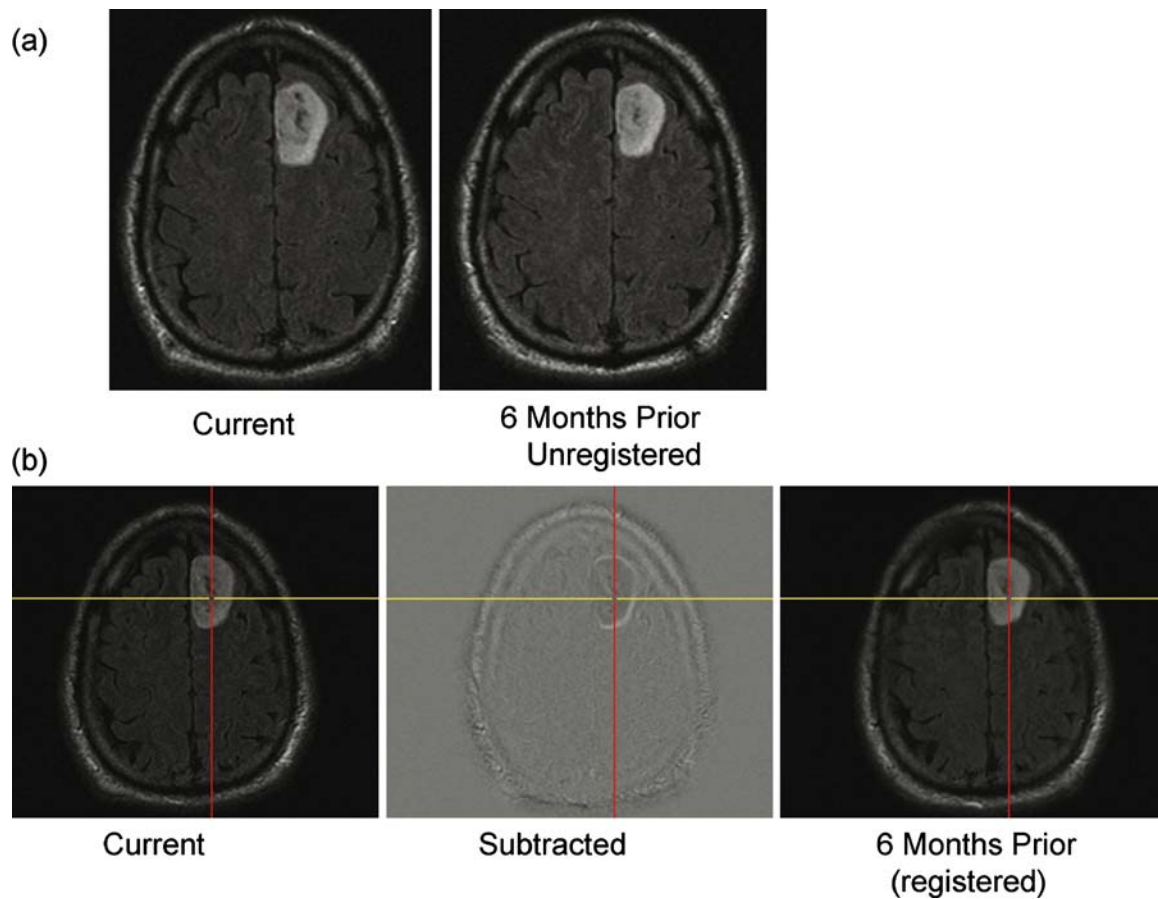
a Shows a single FLAIR image from the current and from a 6 months previous examination in a patient with an oligodendroglioma. Two of three observers indicated probable increase in size over the interval. b Shows the registered images as well as a subtraction image (subtraction was not provided for this study) which clearly demonstrates interval progression.
